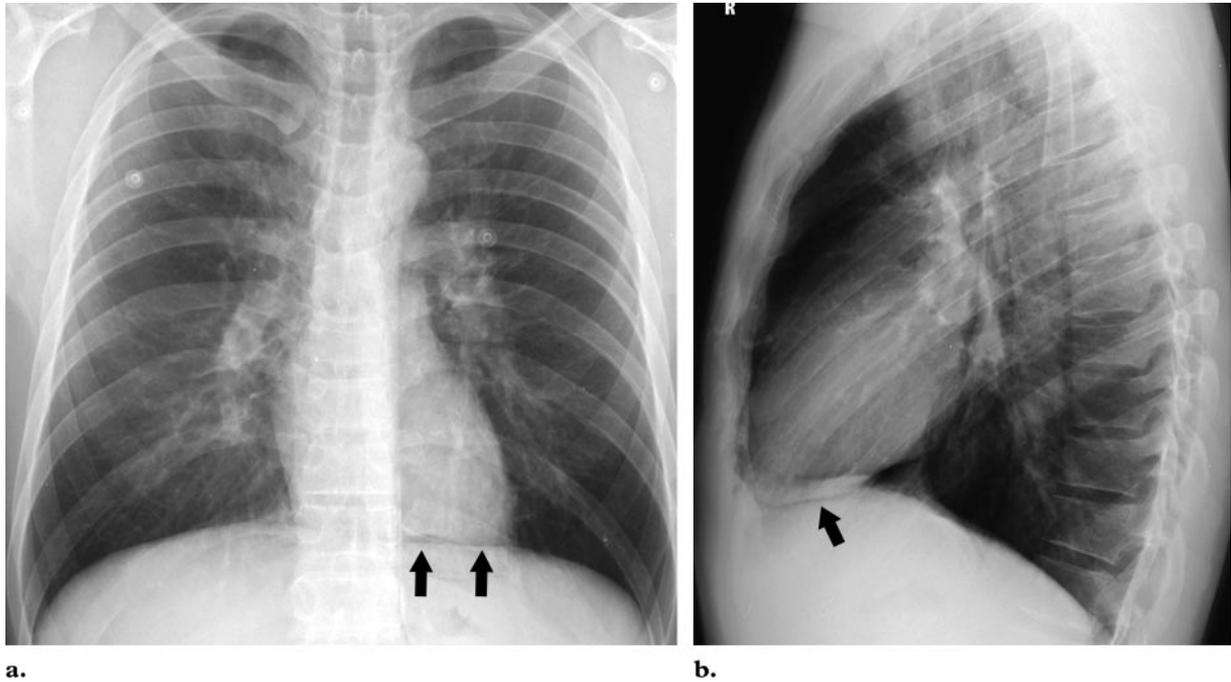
Pneumomediastinum in a 28-year-old patient who presented with retrosternal chest pain after smoking crack cocaine. Posteroanterior (a) and lateral (b) chest radiographs show a lucent line extending into the anterior mediastinum (arrows).
